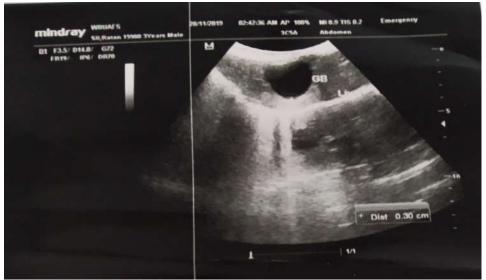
ULTRASONOGRAPHIC IMAGE SHOWING DISTENDED GALLBLADDER
